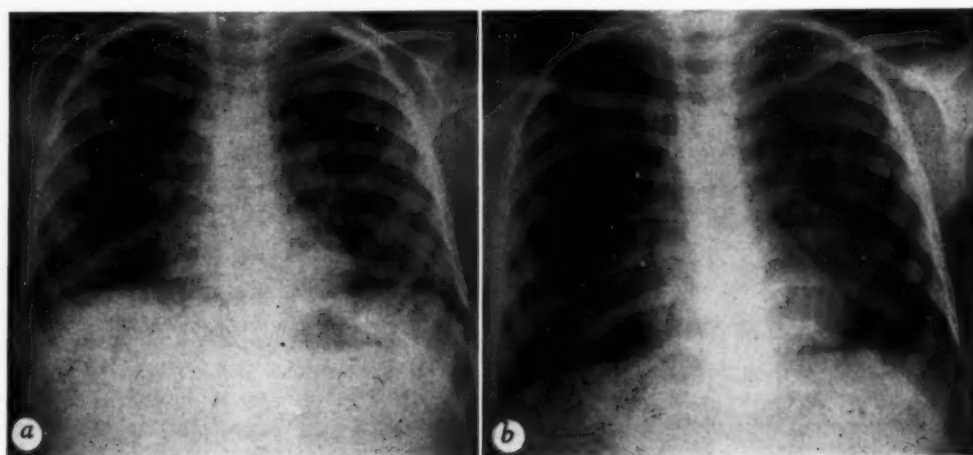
Case 5. Thoracic roentgenograms, (a) before and (b) several years after treatment.
